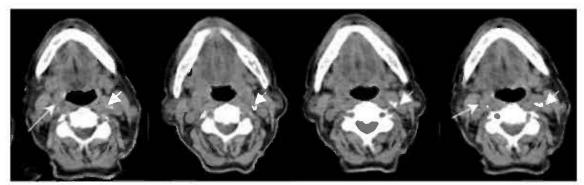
I Unenhanced axial CT images of the neck show multifocal calcifications of the wall of the major neck vessels. The left artery (short arrows) is more affected than the right artery (long arrows). Without intravenous contrast administration, the vessels are not easily distinguishable from the surrounding musculature structures.
